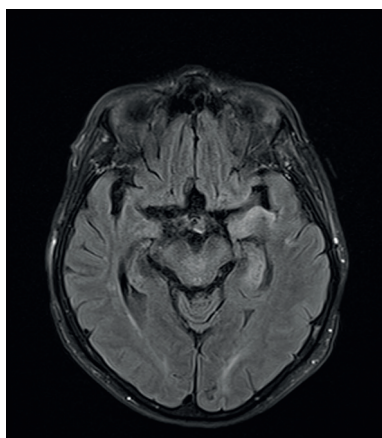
Panel A. Brain MRI
